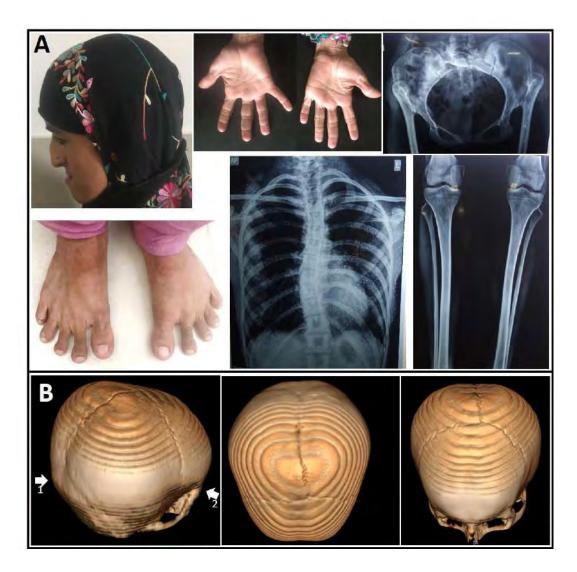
Phenotypic in affected patient 502. Pictures and X-ray images of affected sib 502. Mandibular prognathia, maxillary hypoplasia, and prominent nose bridge; thin cylindrical fingers with extra ventral phalangeal creases and shortening of fifth fingers; hypoplasia of pelvic girdle with short iliac wings, malformation of acetabula and asymmetrically and posteriorly dislocated femoral heads that articulated with the posterior aspects of iliac crests; narrowly aligned tibiae and fibulae, and hypoplastic and malpositioned patellae; general osteopenia and lack of maturation of tubular bones as evidenced by visible metaphyseal lines, unfused metaphyseal lines and poor bone mineralization; general delayed bone age indicated by the epiphyseal gaps at the end of long bones and delayed closure of epiphyseal lines; scoliosis of thoracic and lumbar spines and dislocated and hypoplastic clavicles; splayfoot; b 3D reconstructions of cranial CT of 503, showing cranial anomalies including incompletely fused sagittal sutures deviating from the medial axis, and asymmetry evident as depressions in the frontal and occipital aspects of the skull (arrows).
